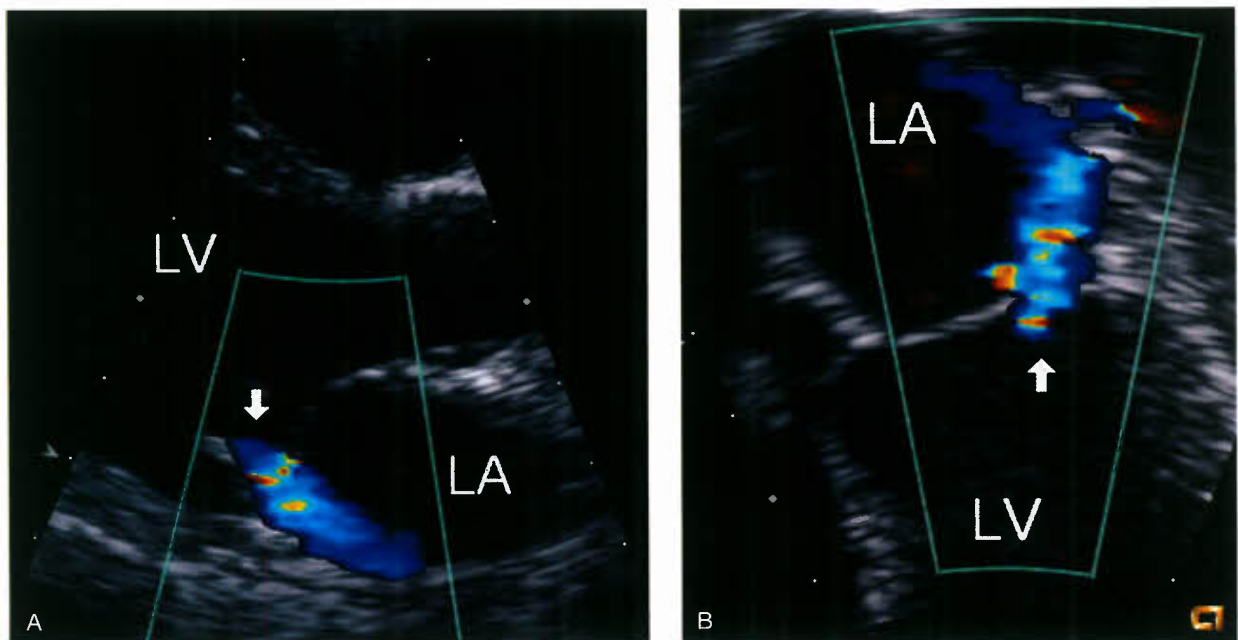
Silent rheumatic mitral regurgitation. Two-dimensional echocardiographic parasternal long-axis (A) and apical four-chamber (B) images showing a posterolaterally directed jet of mitral regurgitation extending into the left atrium well beyond the mitral valve leaflets.
